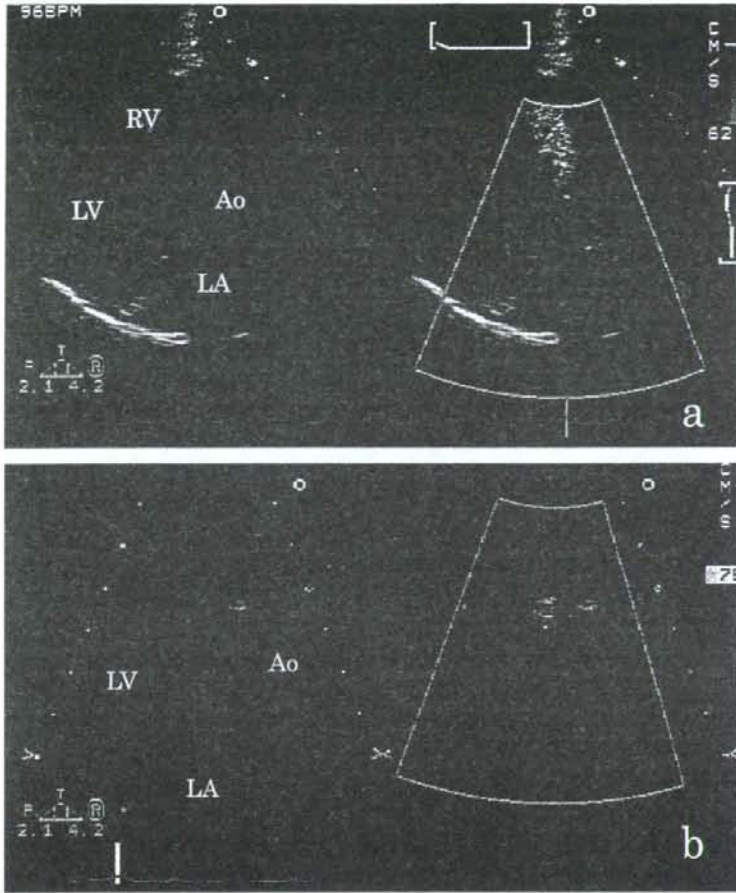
Echocardiograms from a 29-year-old woman who was diagnosed with a small ventricular septal defect during her first pregnancy. Shunt flow increased in third trimester of her pregnancy (a) compared with 1 year after her delivery (b). Her left atrial dimension was 44mm during pregnancy. In contrast, it was 38mm after delivery.
